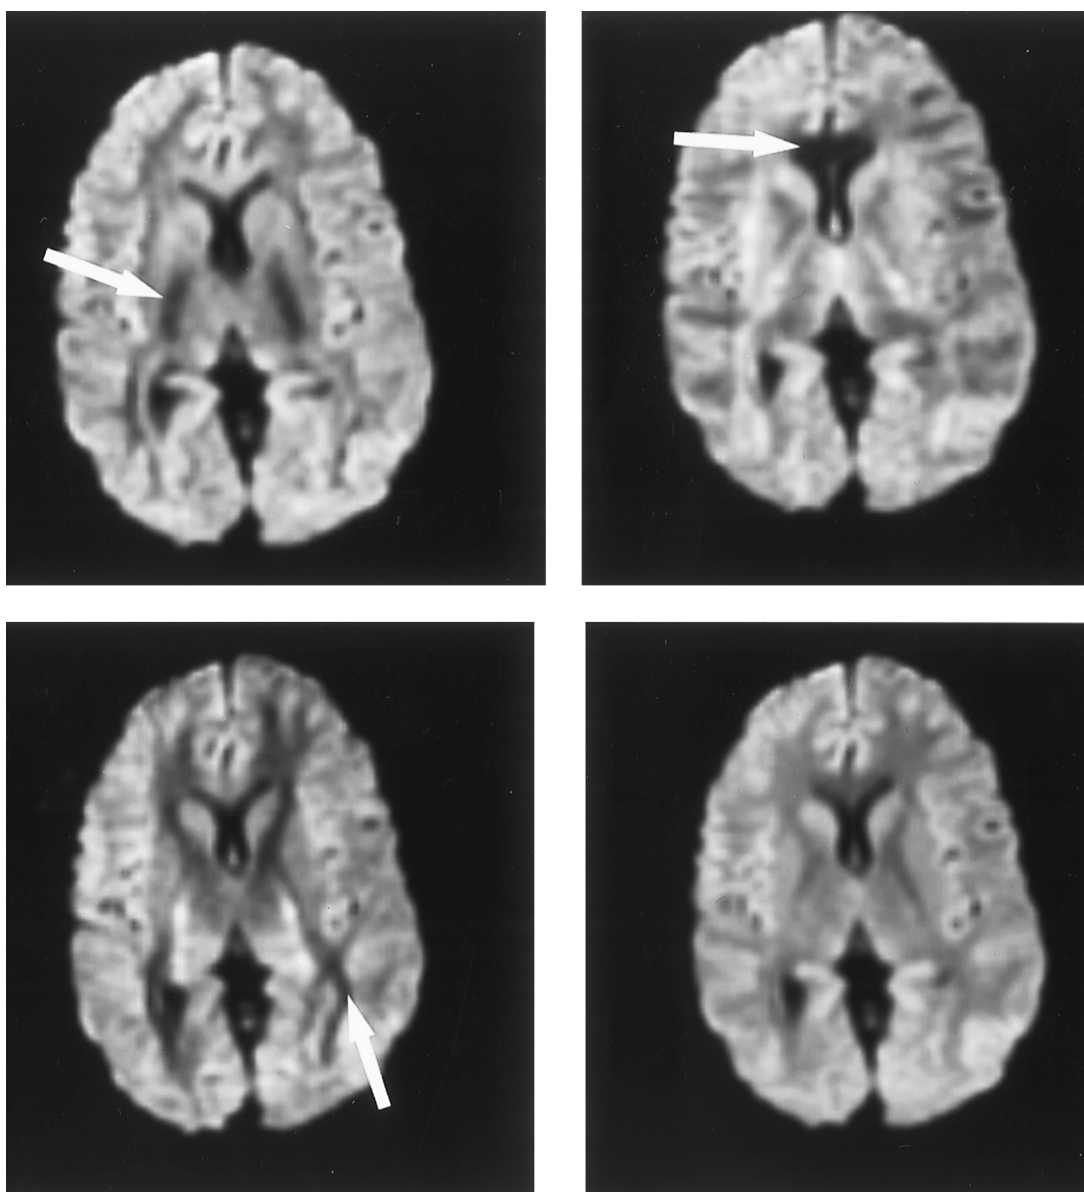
Diffusion-weighted MR images with diffusion-sensitizing gradients applied in the superoinferior (top left), right-left (top right), and anteroposterior (bottom left) directions. Note the dramatic differences in image appearance due to the anisotropic nature of water diffusion within the white matter tracts (arrows). Signal intensity is hypointense in directions of less restricted diffusion (along the tracts). The trace image (lower right) does not exhibit such anisotropic effects.
